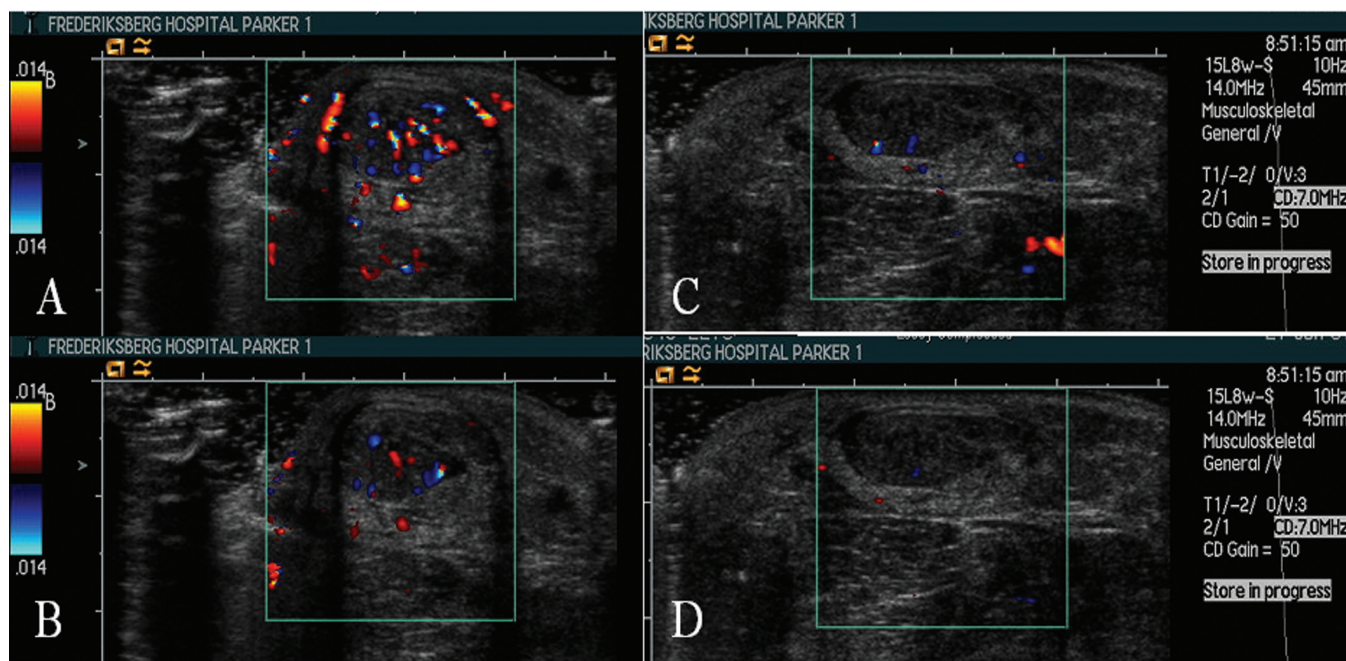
Pressure artefact in Achilles tendinosis. Image A and B are transverse images of the Achilles tendon with very light transducer pressure. A shows the intratendinous Doppler activity in the systole and B in the diastole. Images C and D are with more transducer pressure, which is demonstrated by a larger skin-transducer contact as well as slight flattening of the tendon. C is in the systole and D is in the diastole. Note the obvious decrease in intratendinous flow in both systole and diastole when pressure is applied. The decrease would erroneously indicate that the tendon was borderline normal (very little intratendinous systolic flow).
